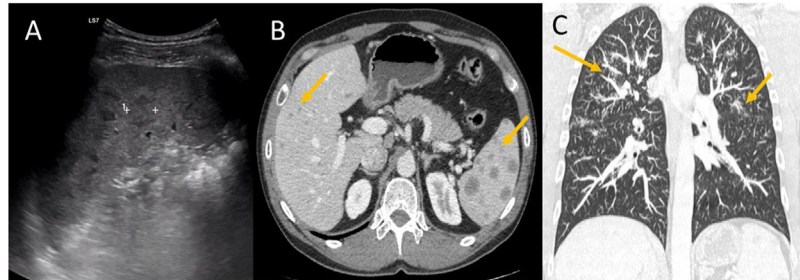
50-year-old male with left hypochondrium pain and anaemia. (A) Baseline ultrasound showing an enlarged spleen with multiple hypoechoic splenic lesions (between cursors) and liver lesions (not shown). In this case, contrast-enhanced ultrasound was not performed. (B) Abdominal computed tomography showing multiple splenic and hepatic hypodense lesions (yellow arrows). (C) Coronal slice of a chest CT scan showing ill-defined lung opacities and some nodules in a perilymphatic distribution (yellow arrows), findings suggestive of diffuse lung involvement due to sarcoidosis. Transbronchial biopsy confirmed the diagnosis of sarcoidosis.
